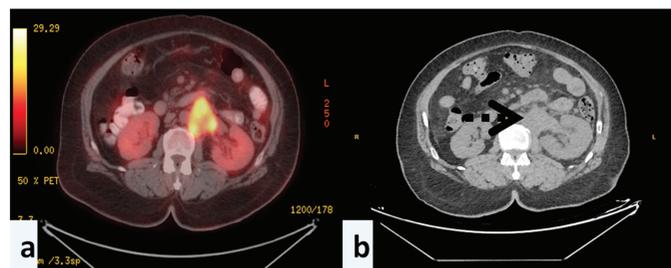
a) PET/CT scan of abdomen showing left adrenal mass in the left paraaortic region invaded the left adrenal gland, left renal pelvis and renal parenchyma; b) CT image of the same lesion
